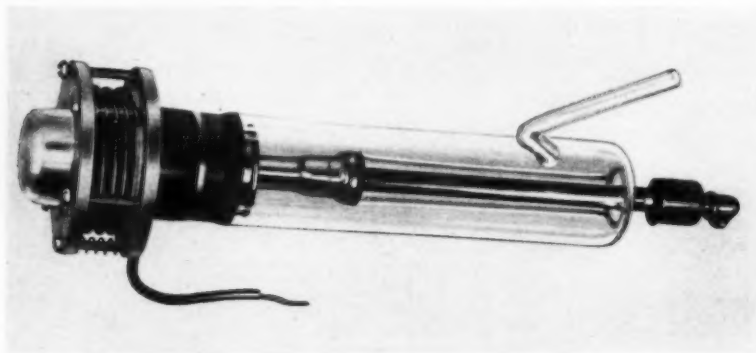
Experimental tube with domed window permitting 180-degree solid angle x-ray beam. (Courtesy Machlett Laboratories, Inc.)
